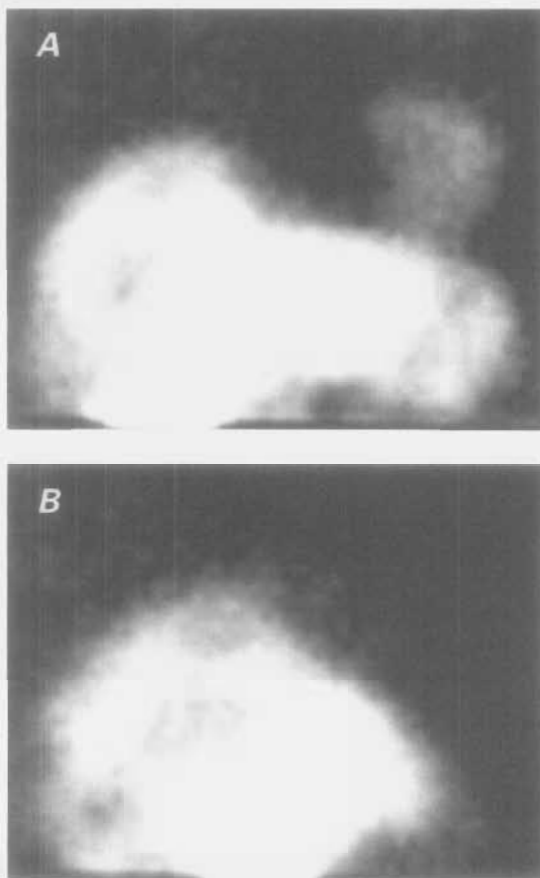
Anterior (A) and lateral (B) projections of the lower thorax and upper abdomen from the unprocessed data of single photon emission computed tomographic myocardial perfusion, which demonstrate multiple areas of photopenia in the liver. The heart is also visualized.
